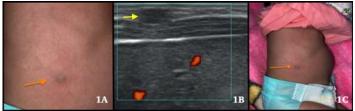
A,C Depicts a superficial venous malformation mimicking a cutaneous hematoma. The image is enlarged to visualize better superficial blood vessels arranged in a telangiectatic pattern draining to the venous malformation (orange arrow in Fig 1A & C). Fig 1B is a Doppler Ultrasound of the nodule, suggesting a slow flow pattern of the vascular malformation and no communication with arterial circulation (the yellow arrow points towards the vascular malformation)
